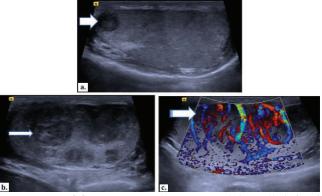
USG scrotum shows a solid well-defined hypoechoic lesion in the right testis (thick arrow in a) and similar multiple lesions in left testis (thin arrow in b) with markedly increased central and peripheral flow on color doppler (striped arrow in c).
